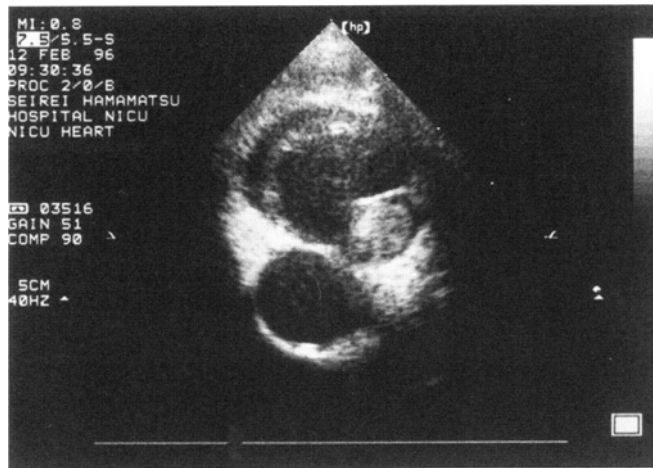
Two dimensional echocardiography in short axis view showed a large thrombus within the remnant main pulmonary artery. The thrombus appeared to float within the stump.
